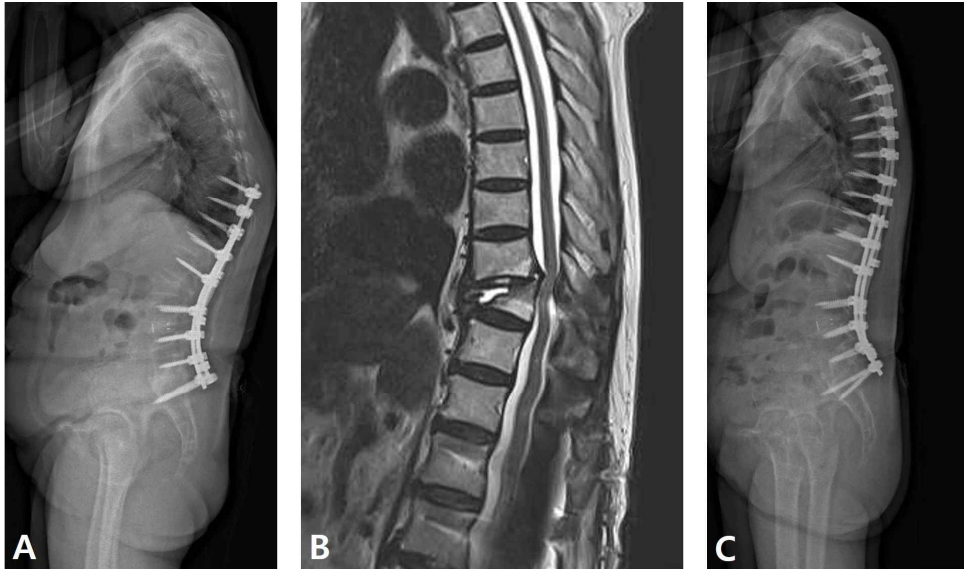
Serial radiographs showing A: Proximal junctional kyphosis with compression fracture of uppermost instrumented vertebra and screw pull-out, B: MRI image showing proximal junctional failure and resultant cord compression, C: Reoperation with decompression and extension of instrumentation up to T4 level.
